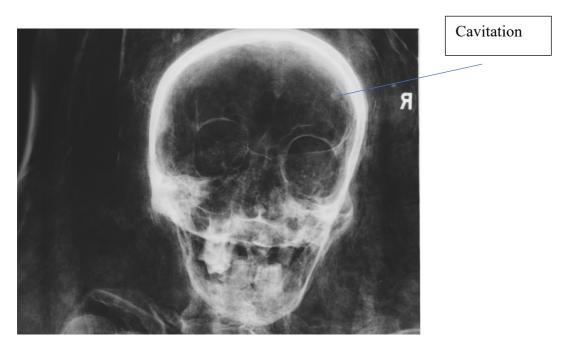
1 Frontal x-ray of cranium showing circular lesion cavitation
